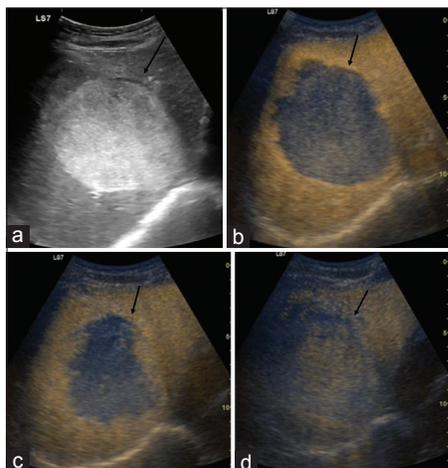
A 60-year-old male patient presented with diffuse abdominal pain. On screening ultrasound, well-defined large hyperechoic lesion in the liver (black arrow, a). Contrast-enhanced ultrasound is done targeting the lesion showing peripheral nodular enhancement in arterial phase at 25 s after contrast injection (black arrow b), gradual centripetal filling in venous at 90 s after contrast injection (black arrow, c), and near complete enhancement after 210 s after contrast injection in the delayed phases (black arrow, d)
